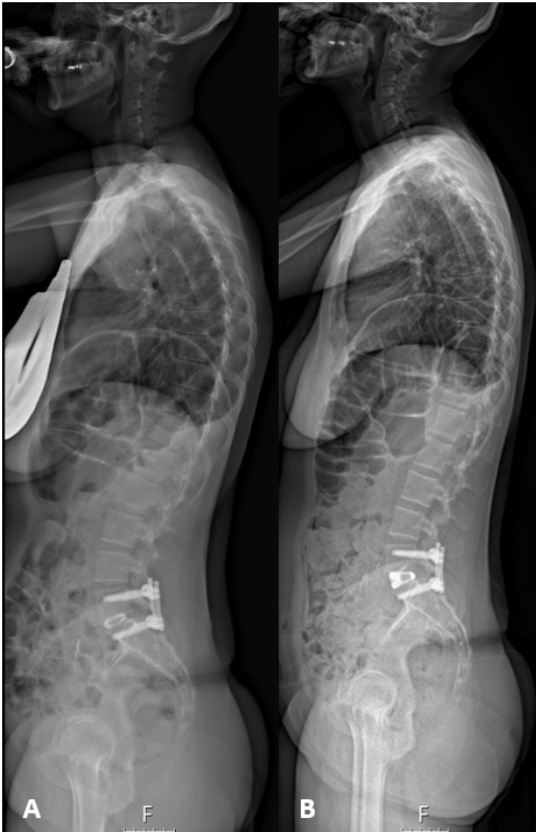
A. Pre and B. post-operative Full standing spine X-Rays-EOS of a L5-S1 ALIF for anterior cage removal and restoration of sagittal balance
